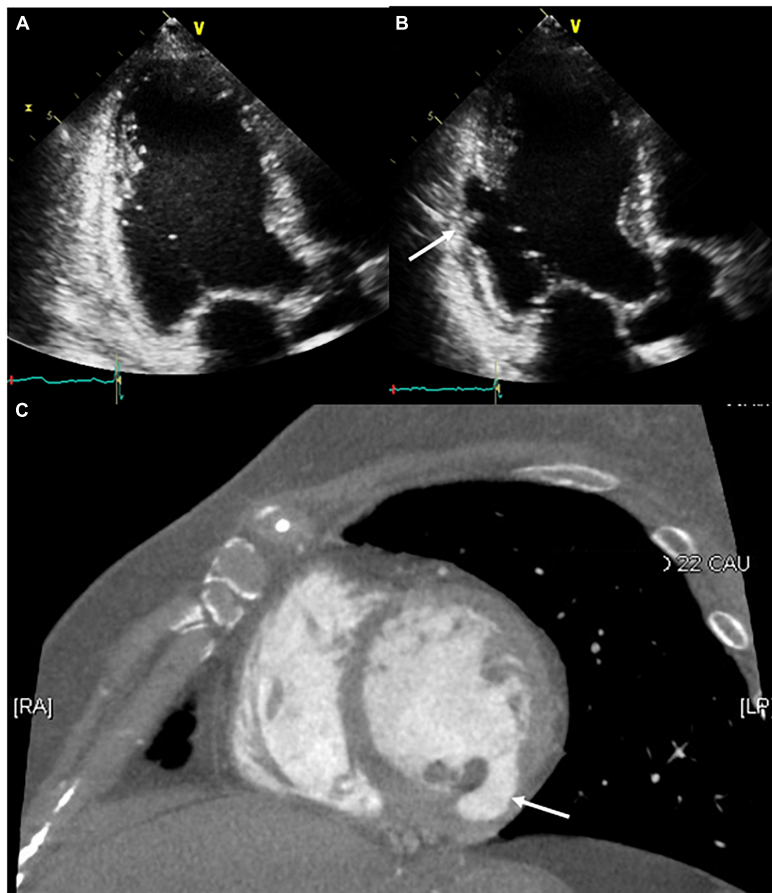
Serial follow-up of the ablation site using transthoracic echocardiography. (A) The day after the procedure, no structural changes around the ablation site were observed. (B,C) After 2 months of follow-up, the development of a pseudoaneurysm on the ablation site (white arrow) was confirmed through transthoracic echocardiography and contrast-enhanced computed tomography.
